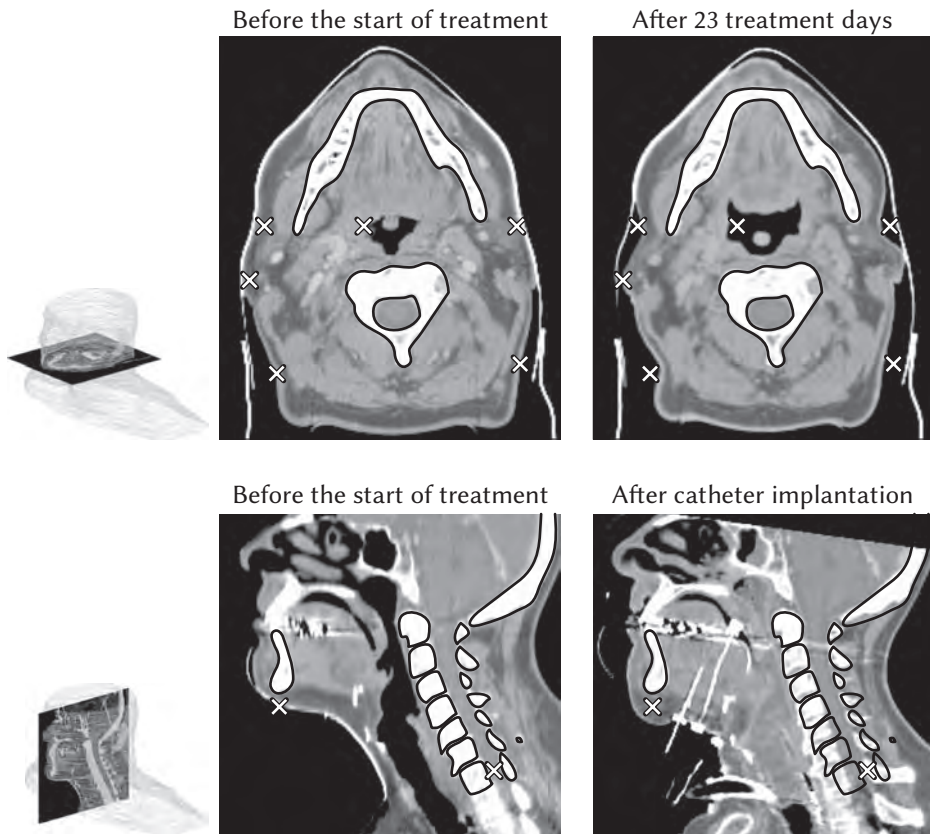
Changes in the anatomy of a patient as observed in CT images. The first row shows changes due to weight loss and tumor shrinkage after 23 treatment days. The second row shows changes due to the implantation of catheters for brachytherapy. Anatomical changes are pointed out by crosses. The contours represent the mandible, spine and skull from the CT acquired before the start of the treatment.
